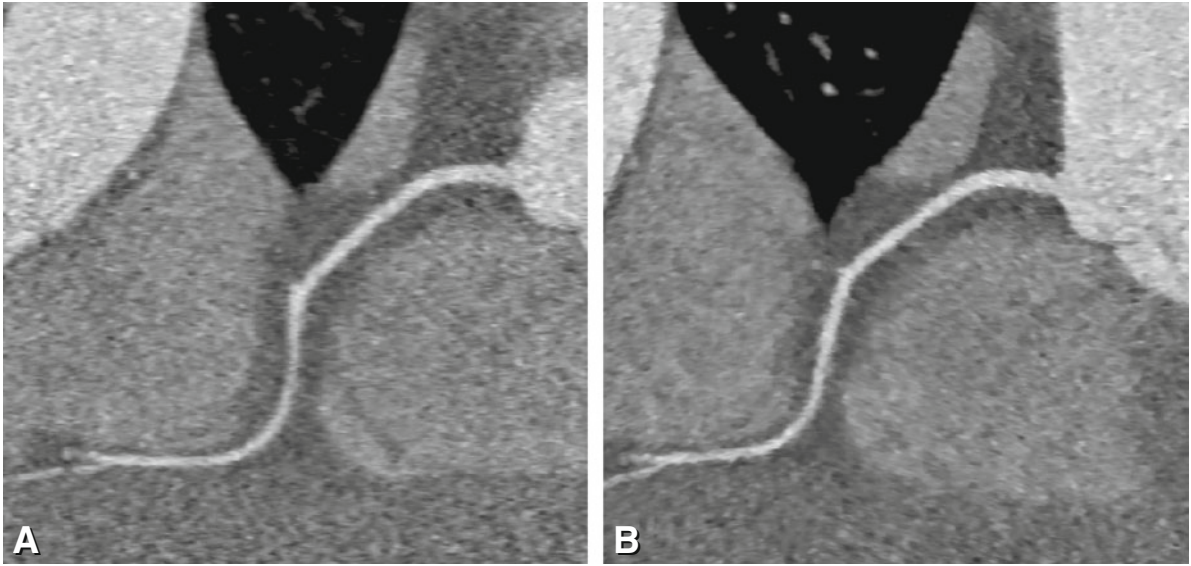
Dramatic reduction of effective radiation dose is possible in selected patients. Example of a curved multiplanar reformation of the right coronary artery reconstructed using filtered backprojection (Panel A) and sonogram-affirmed iterative reconstruction (Panel B) in a patient with a slow and stable heart rate of 53 beats per min and a weight of 62 kg at a height of 170 cm. Scanning was done by using 80 kV and 50 mAs, resulting in a dose-length product of only 4 mGy.cm (Used with permission from Schuhbaeck et al. *Eur Radiol* 2013a)
